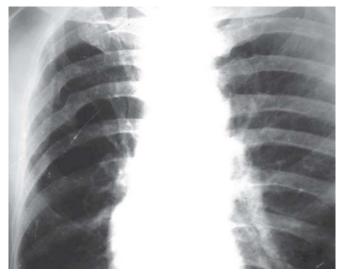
Plain X-ray showing rib fracture
